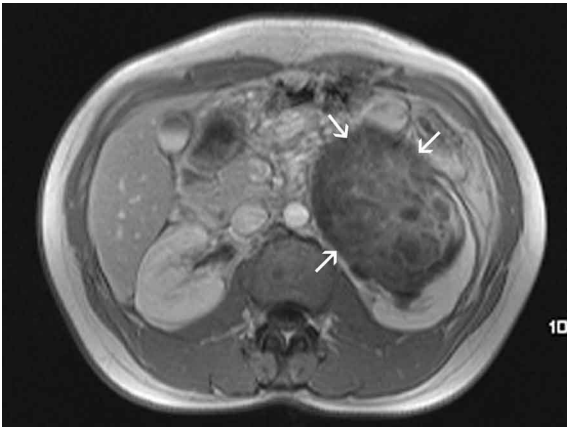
Magnetic resonance images demonstrate a tumor with heterogeneous high-signal intensity on the T2-weighted pulse sequence (arrows).
